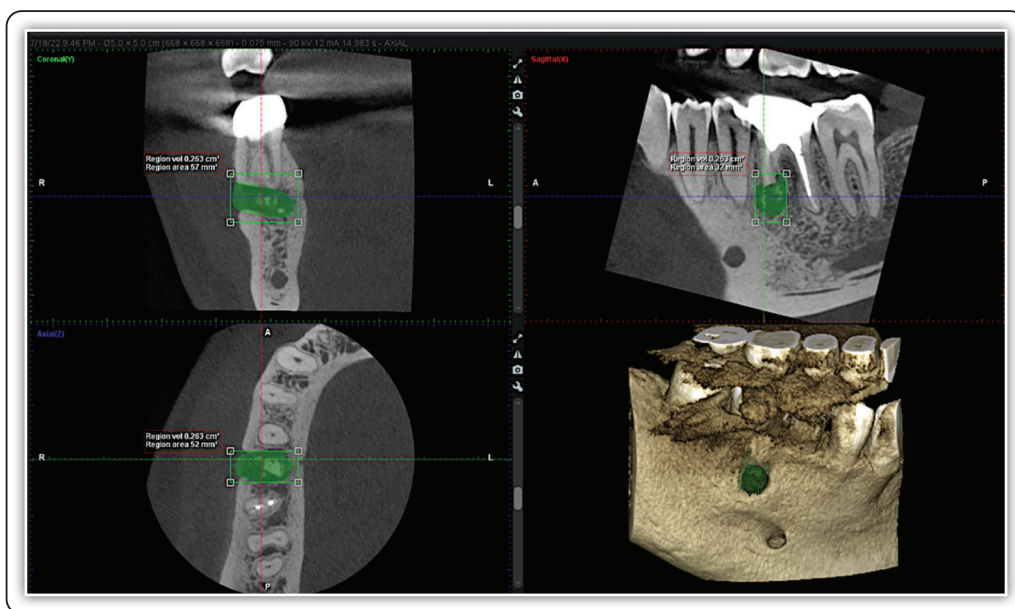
Immediate post-operative CBCT scans
